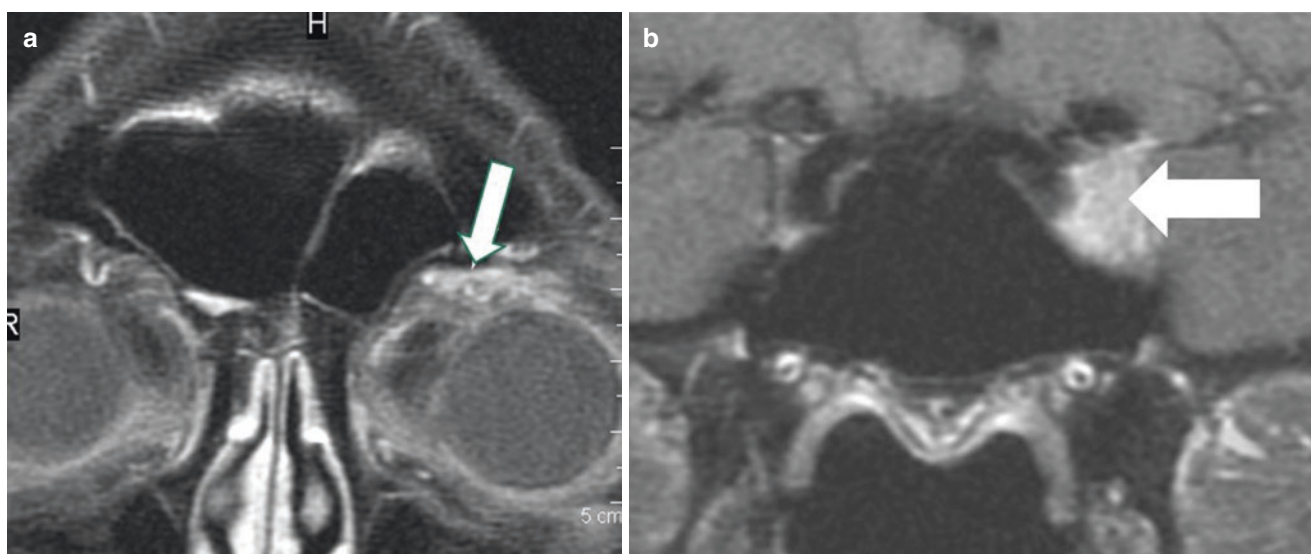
A patient with previously removed left forehead skin cancer and abnormal sensation in the distribution of the ophthalmic division of the trigeminal nerve. (a) Fat-suppressed, contrast-enhanced T1-weighted MR coronal image shows infiltration of the fat pad around
